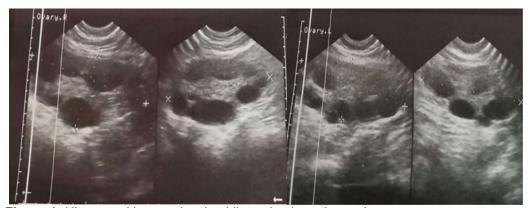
Ultrasound image showing bilateral polycystic ovaries.
